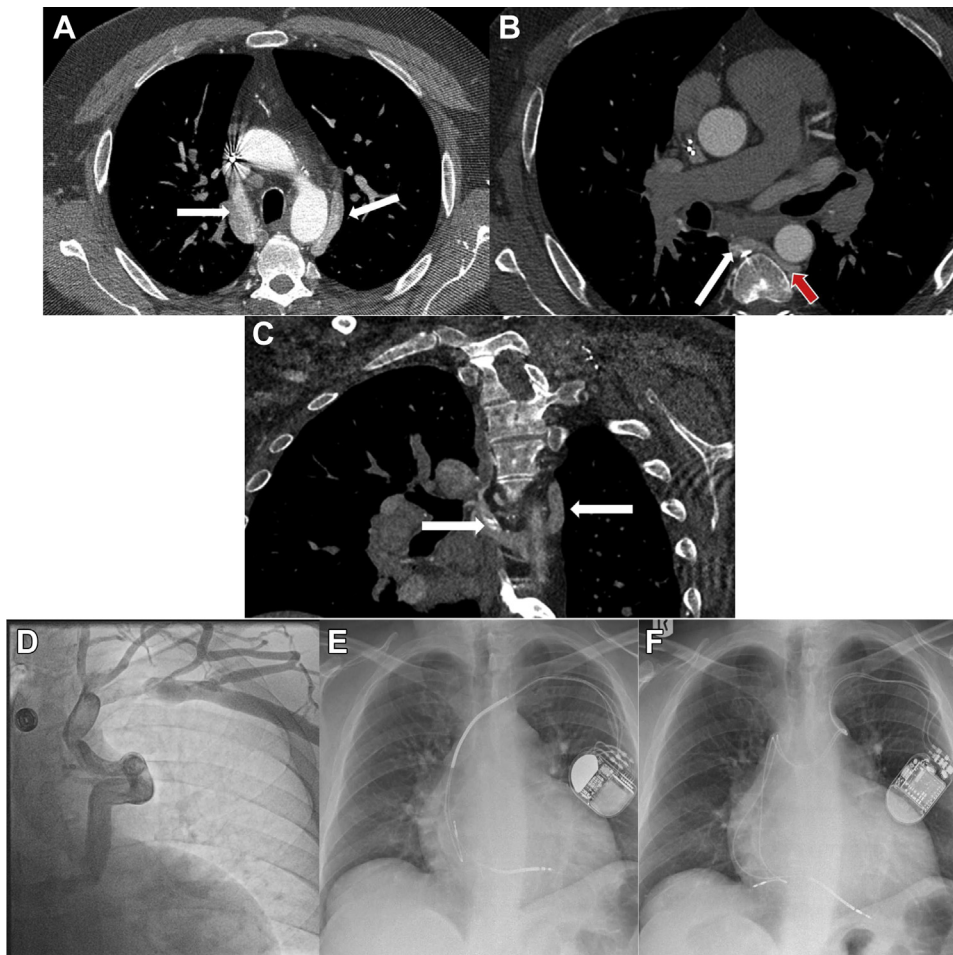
A: Axial contrast-enhanced computed tomography (CT) showing bilateral superior vena cava (SVC) (white arrows). B: Left SVC draining into accessory hemiazygos (red arrow) to azygos vein (white arrow). C: Coronal contrast-enhanced CT with bilateral SVC (white arrows). D: Venous angiography demonstrating collateralization and drainage of the left upper limb via the accessory hemiazygos vein. E: Chest radiograph (posteroanterior projection) showing lead positions prior to whole-system extraction. F: Final lead positions following reimplantation via accessory hemiazygos vein.
